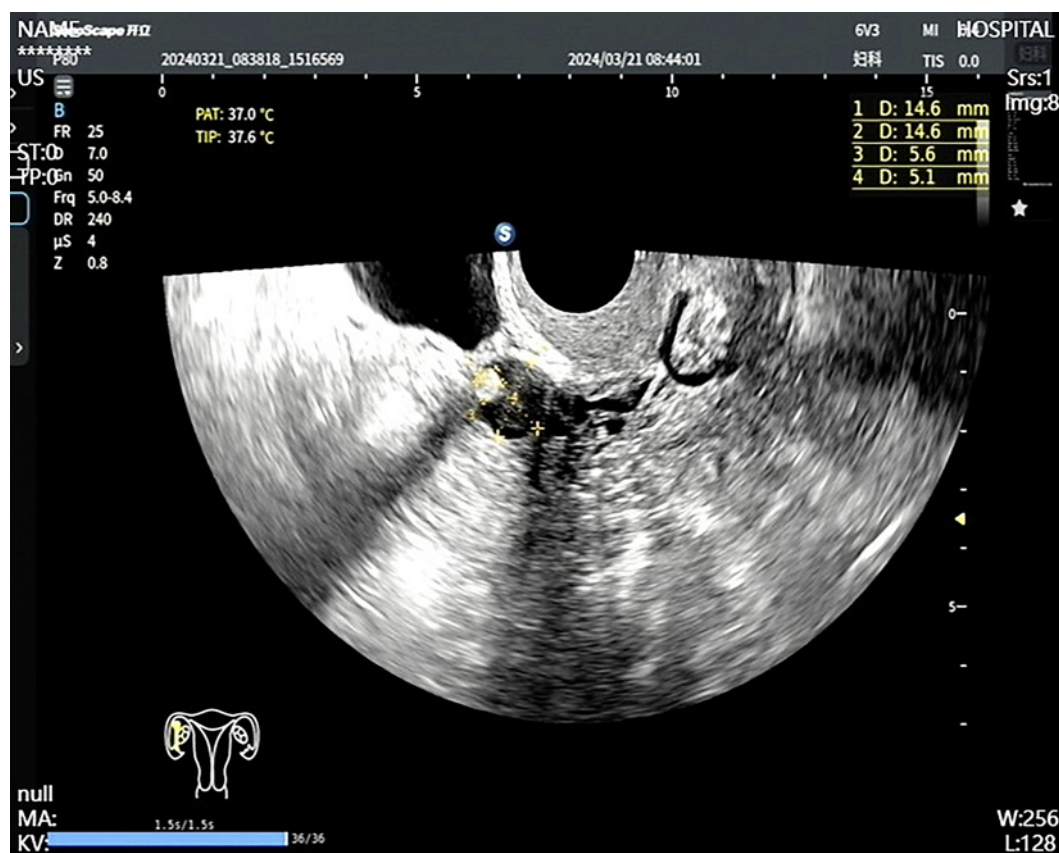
Transvaginal sonography of right ovarian mass.
